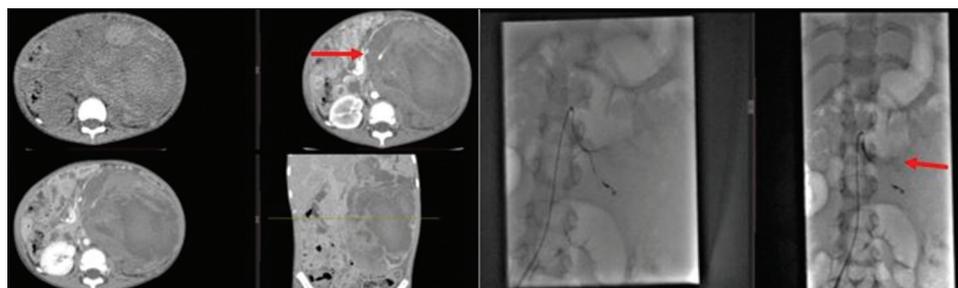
Computed tomography scan abdomen (angiogram) showing high-density hemorrhage within the tumor with active extravasation of contrast, followed by angioembolization left renal artery
